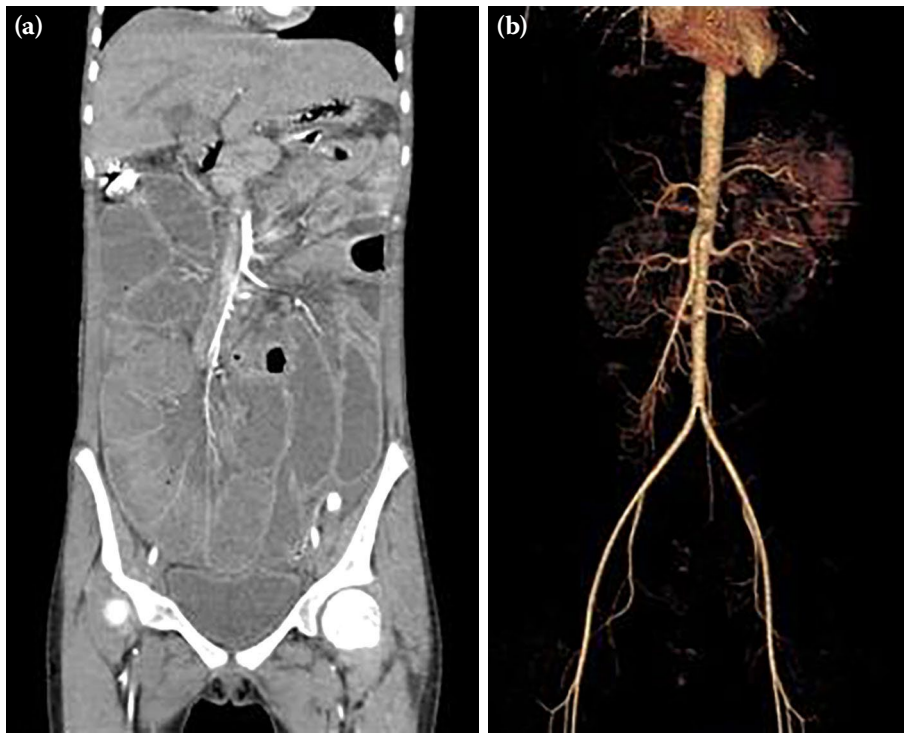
Normal vascular configuration on CT angiography. (a) Coronal CT angiography view showing no signs of vascular occlusion or abnormality. (b) 3D reconstruction image further confirming a normal anatomical and vascular configuration, effectively ruling out any vascular pathology. No statistical comparisons were performed. CT, computed tomography; 3D, three-dimensional.
